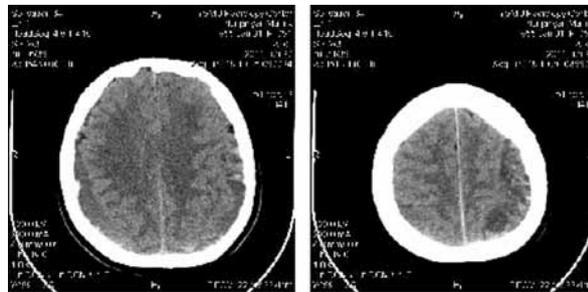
CT of the brain before the operation
